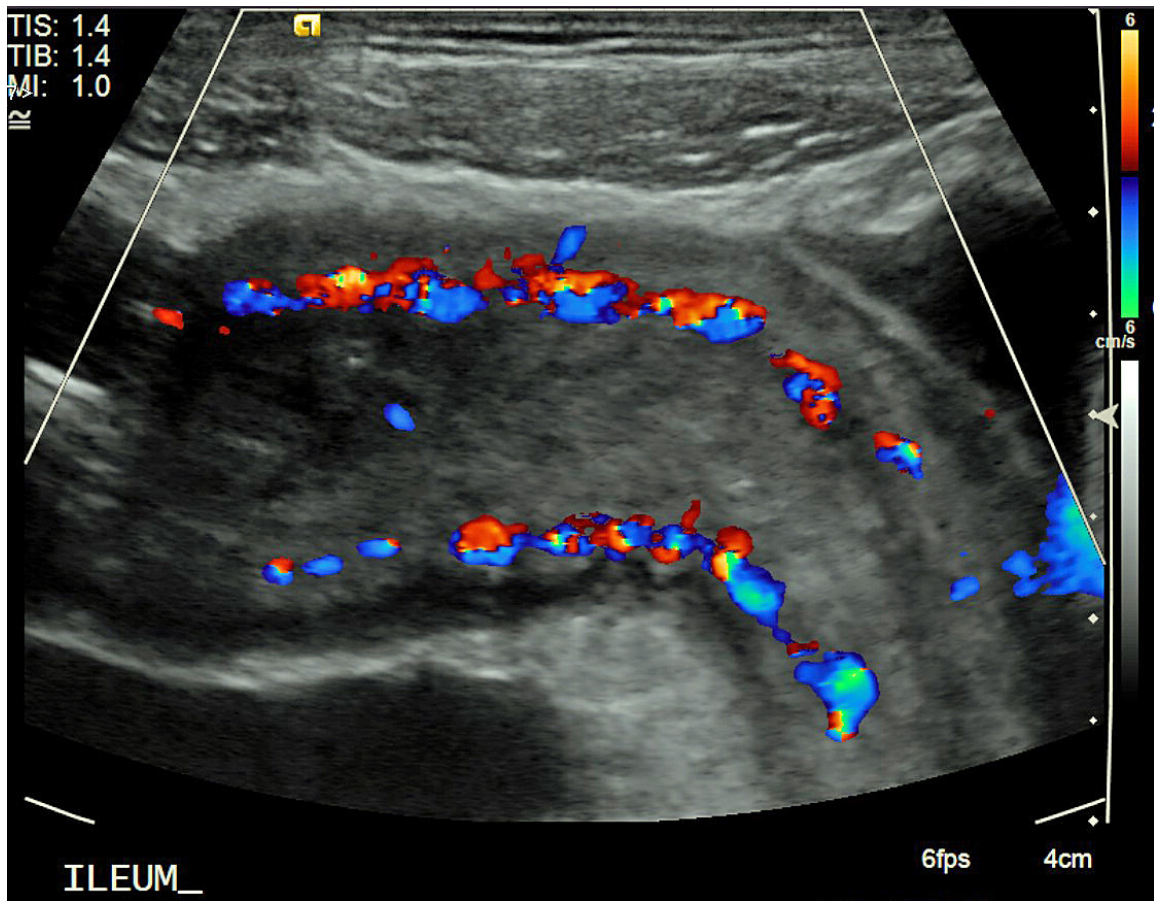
Ultrasound with color Doppler of same patient with Crohn's Disease prior to medical therapy. Note loss of bowel wall signature and hyperemia. This loop of bowel is surrounded by free fluid.
